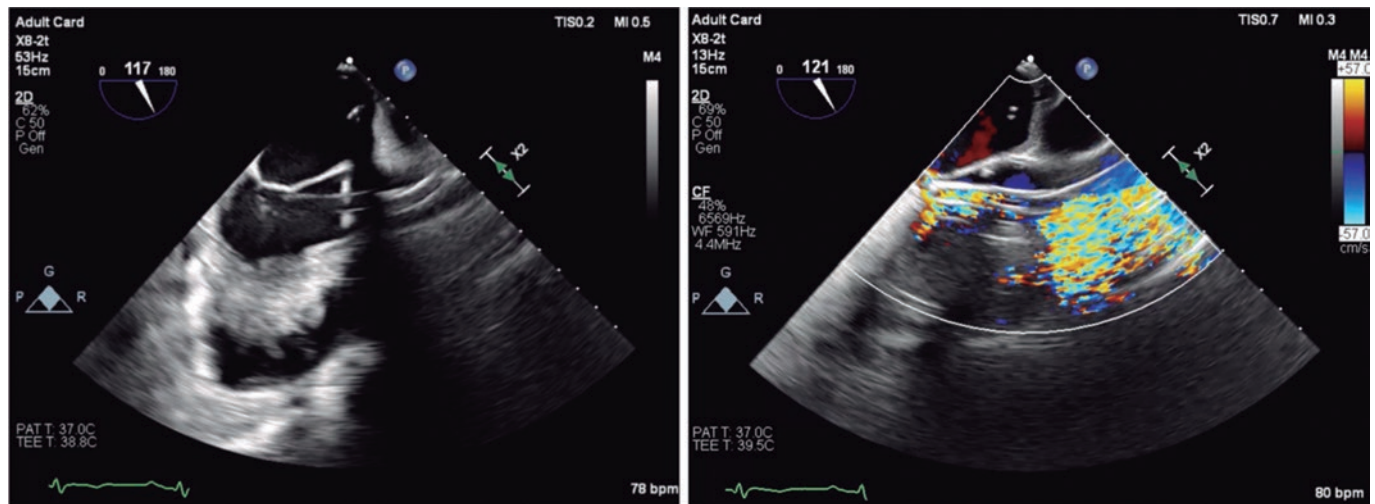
Normal position of the Impella device as seen on the transesophageal echocardiography.
